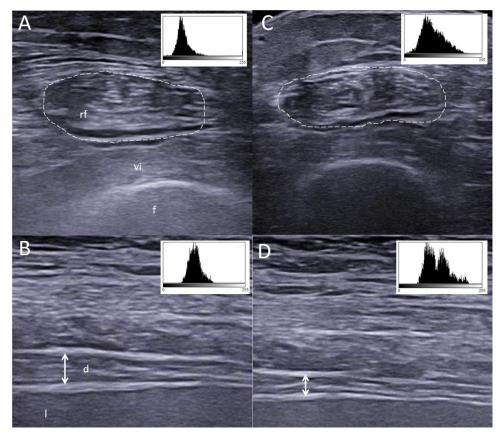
Muscle ultrasound images at ICU admission (A) and on day 7 (B) from a representative patient. A and B show the rectus femoris and diaphragm, respectively, at ICU admission in a representative patient. C and D show the same muscles in the same patient on day 7 after ICU admission. The area enclosed in the white dashed line is the rectus femoris cross-sectional area; the arrowhead line indicates the diaphragm thickness. The histogram of muscle echo density is shown on the top right corner of each panel. d, diaphragm; f, femur; l, liver; rf, rectus femoris; vi, vastus intermedius.
